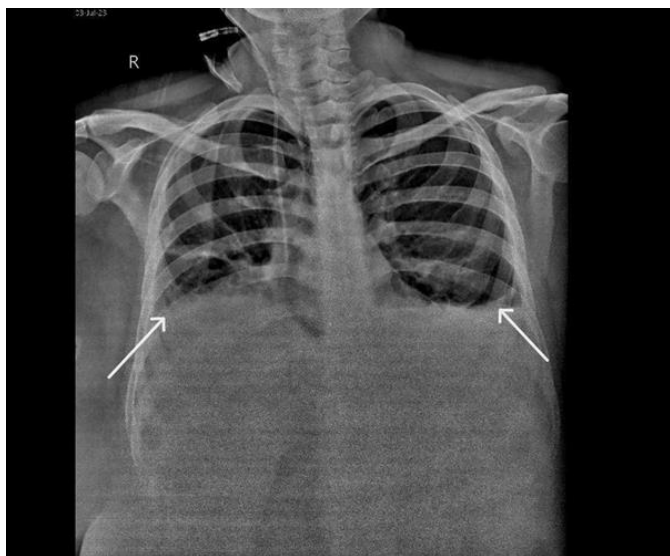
A 46-year-old female presented with the complaint of breathlessness subsequently diagnosed as pancreaticopleural effusion – Plain Chest radiograph in posteroanterior view (i) Bilateral
